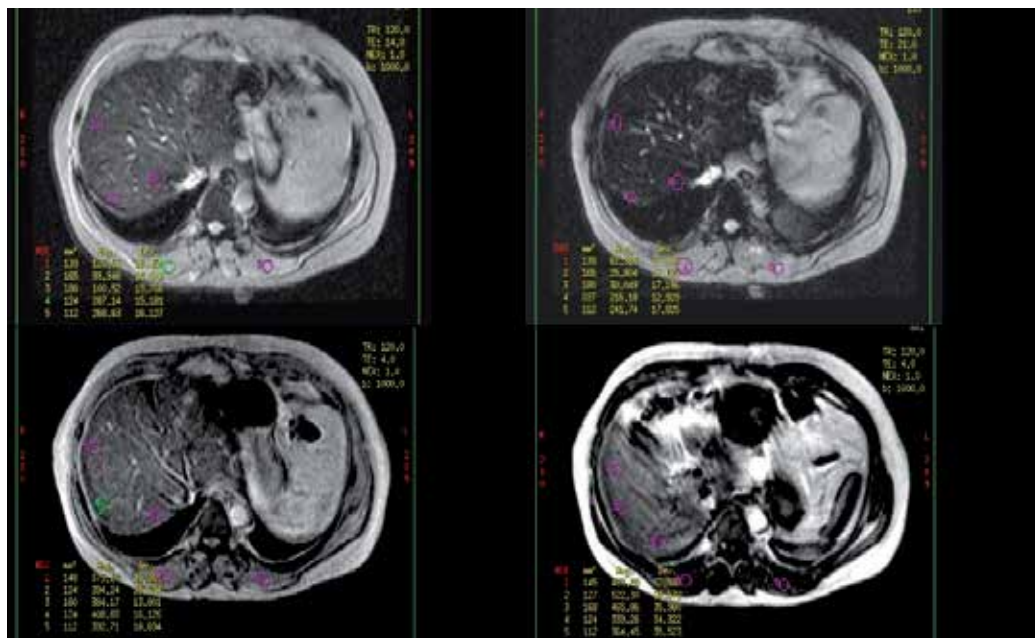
Magnetic resonance imaging quantification of hepatic iron stores according to the method of Rennes University
